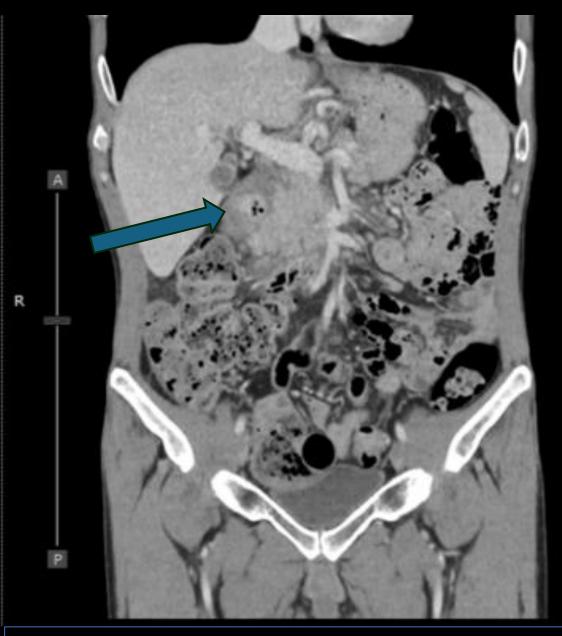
Coronal CT: Fluid in the region of the D2 flexure and pancreatic head (blue arrow)
